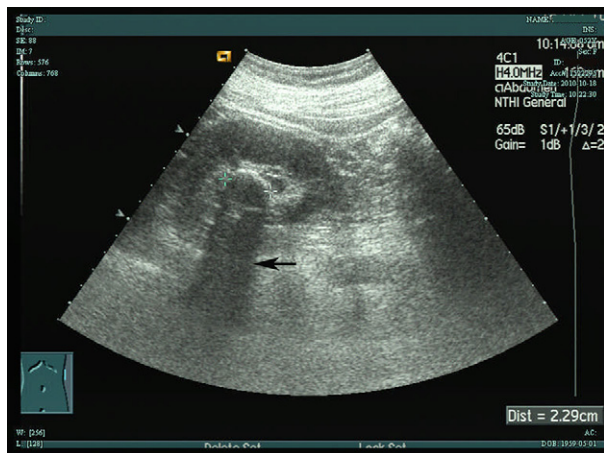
Duplex ultrasonographic examination shows a hyperechoic focus in the left renal pelvis with acoustic shadow (arrow).
